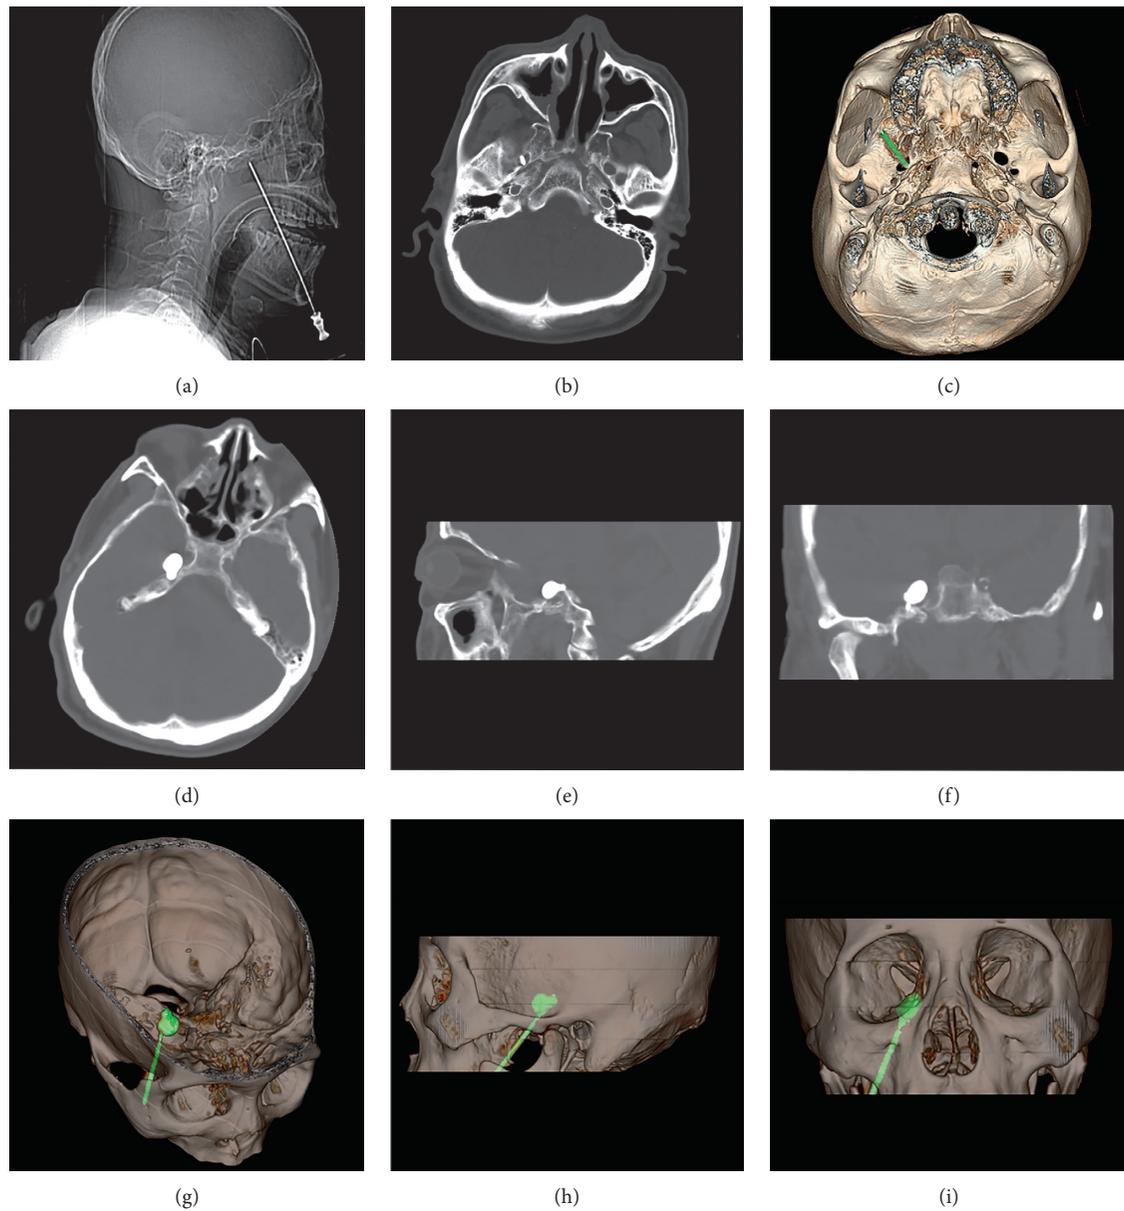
2D images and reconstructed 3D-CT images during FO puncture. (a) Scout image of spiral CT during FO puncture; (b), (c) 2D and reconstructed 3D images of spiral CT showing the spatial relationship between the needle and the targeted FO; (d-f) axial, sagittal, and coronal views of the pear-shaped balloon; (g-i) reconstructed 3D-CT images provided confirmation of the position and shape of the balloon.
